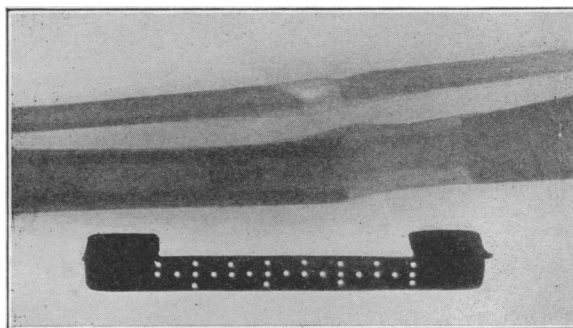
Anteroposterior roentgenogram of tibia and fibula two and one-half months after operation. A gain of one and three-fourths inches was secured.
